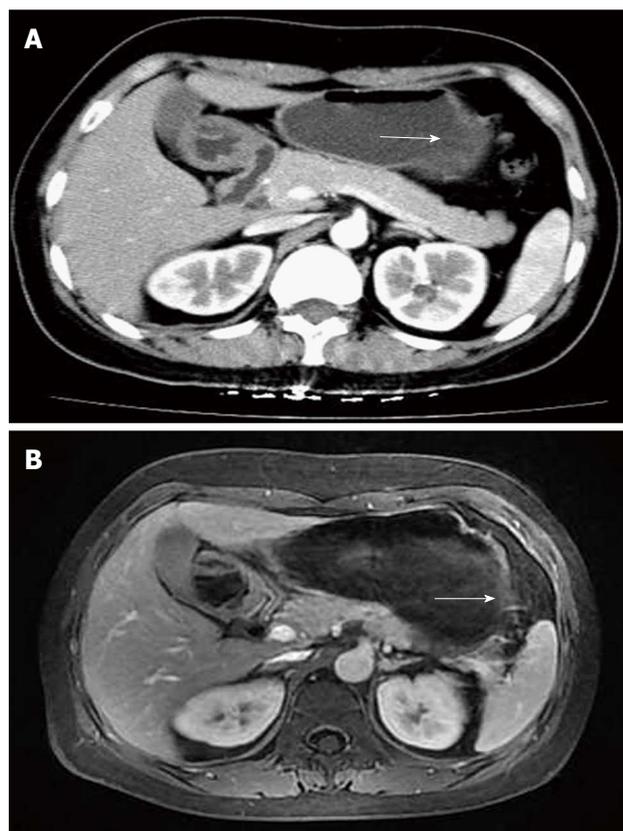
Radiology. A: Computed tomography; B: Magnetic resonance imaging of the patient in a prone position showed that the gastric wall of the stomach at the greater curvature of the antrum was markedly and irregularly thickened, with mild to moderate enhancement (arrow).
